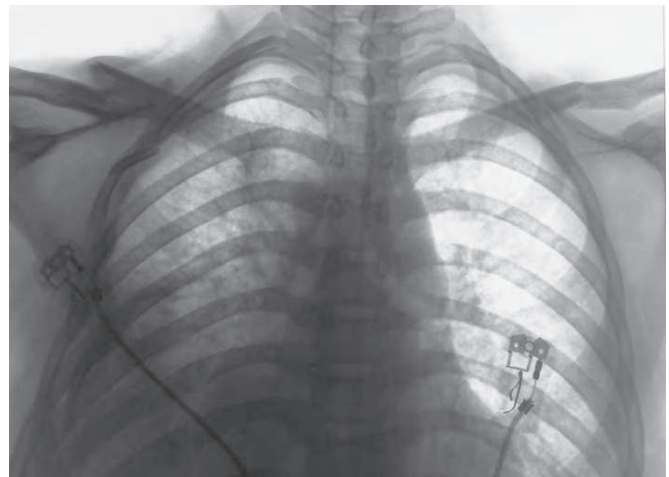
Right hemothorax: The chest radiograph showing diffuse opacification of the right hemithorax through which lung markings can be seen
